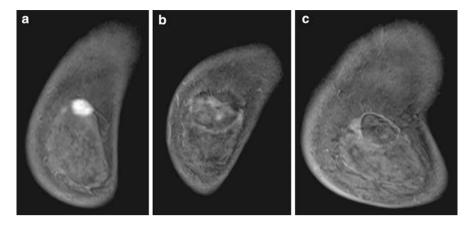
(a–f) Coronal views on MRI scans before (*Pre*) and 1, 6, 12, 24, 36, and 60 months in a 44-year-old woman with a 15 mm invasive ductal cancer who underwent RFA followed by whole-breast irradiation. The mass is no longer enhanced after RFA. The peripheral enhancement was seen 6 months after RFA. And an ablation zone with peripheral ring enhancement has gradually decreased in size. The long-axis diameters measured on each view were 50, 45, 40, and 10 mm, respectively
